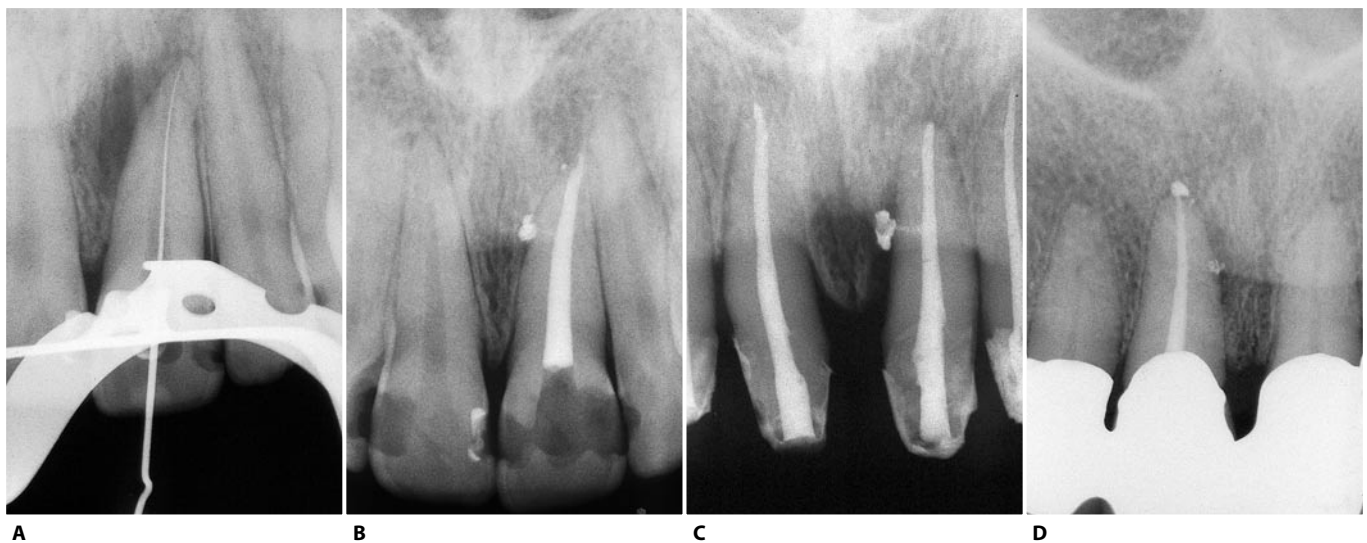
A. Intraoperative radiograph of the upper left central incisor. Note the discrete radiolucency situated mesially to the root. This lesion suggests the presence of at least one lateral canal. B. Twelve months later. Note the healing of the lesion and three lateral canals filled, one near the apex and two at the level of the middle one third, both facing mesially. C. Upper left central incisor with a large lateral canal at the level of the middle one third. The lateral canal faces mesially and branches off from the main canal at a 90° angle. D. Upper right central incisor with a small lateral canal near the foramen and another bigger one in the middle one third, facing mesially at a 90° angle.
